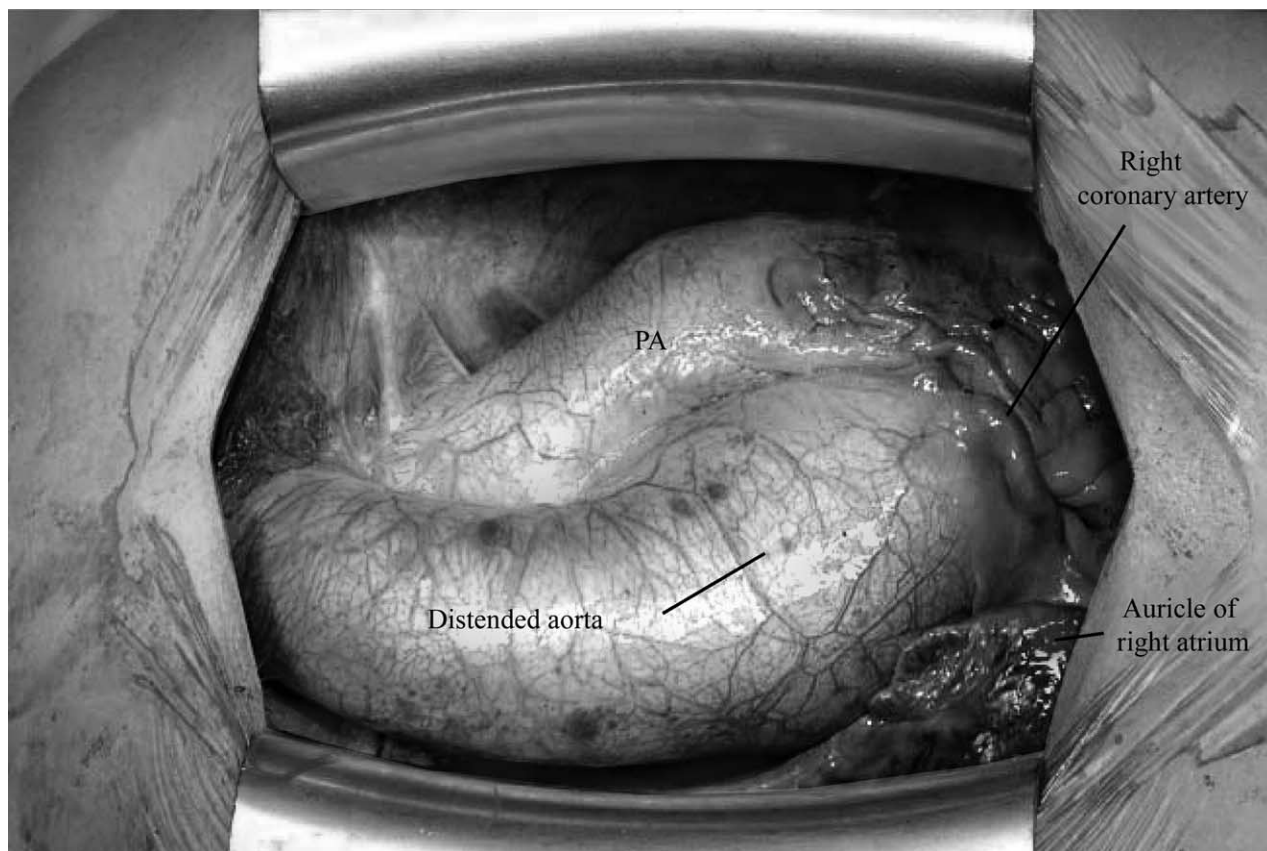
The surgeon's view of the ascending aorta of a 26-year-old female patient with Marfan syndrome with a typical aortic root aneurysm 5 cm in diameter. The preoperative echocardiography revealed only mild aortic regurgitation. The onion-shaped aneurysmatic dilation is confined to the proximal ascending aorta, while its distal segment is not dilated. As with many ascending aortic aneurysms, the heart is rotated posterolaterally, which sometimes hides the right atrial appendage. The ascending aorta may now be cannulated. Venous drainage is accomplished by a 2-stage cannula, unless there is evidence of a shunt on the atrial level, which requires for bicaval cannulation to prevent from aspiration of air into the heart-lung machine once the aorta is opened. On full extracorporeal circulation, the heart is fibrillated before a vent catheter is introduced into the left ventricle through the right upper pulmonary vein to prevent from instant left ventricular over distension, which may develop due to aortic regurgitation. In addition, the vent catheter is very helpful to clear the operative field from residual blood flowing through the pulmonary veins. Then, the distal ascending aorta is cross clamped carefully before the aorta is opened and completely transected. Because of the distal progression of aortic root dilation, the sinotubular junction may sometimes have disappeared. In this condition, the aorta should be incised 3 to 5 mm distal to the estimated level of the former sinotubular junction to prevent from injury to both the right coronary ostium and aortic valve commissure between the right and the noncoronary sinus. This is particularly important in patients with Marfan syndrome, in whom both structures may have drifted surprisingly far downstream within the aortic root.
